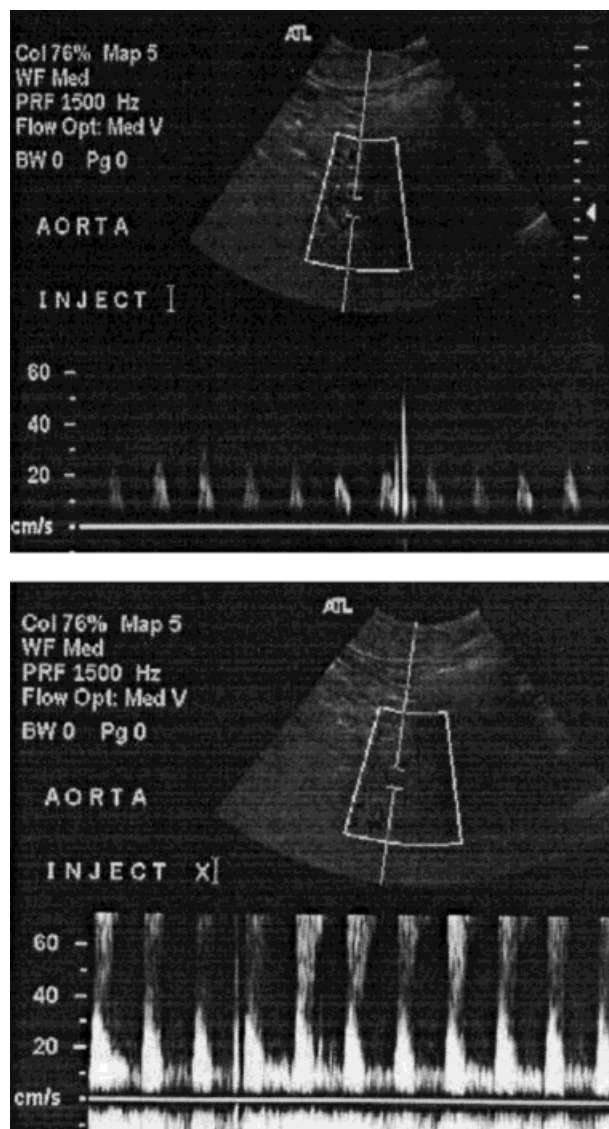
Spectral Doppler ultrasound of the abdominal aorta pre (top) and post (bottom) microbubbles shows the characteristic increase in spectral Doppler signal upon arrival of the bolus.
